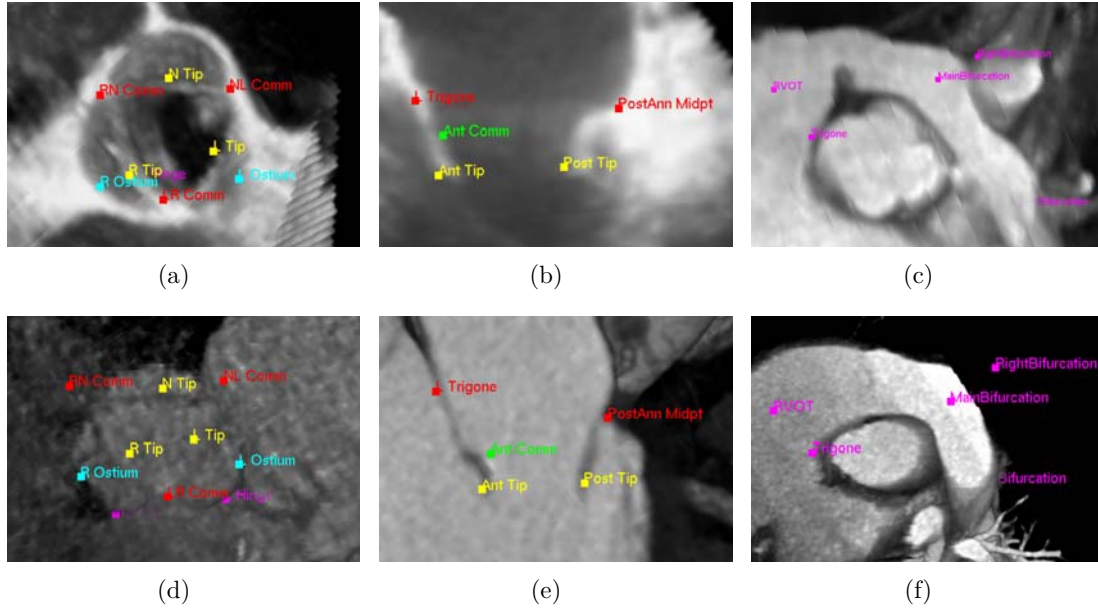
Examples of non-rigid landmark motion estimation: (a) aortic valve in TEE, (b) mitral valve in TEE, (c) pulmonary valve in CMR, (d) aortic valve in cardiac CT, (e) mitral valve in cardiac CT, and (f) pulmonary valve in cardiac CT.
